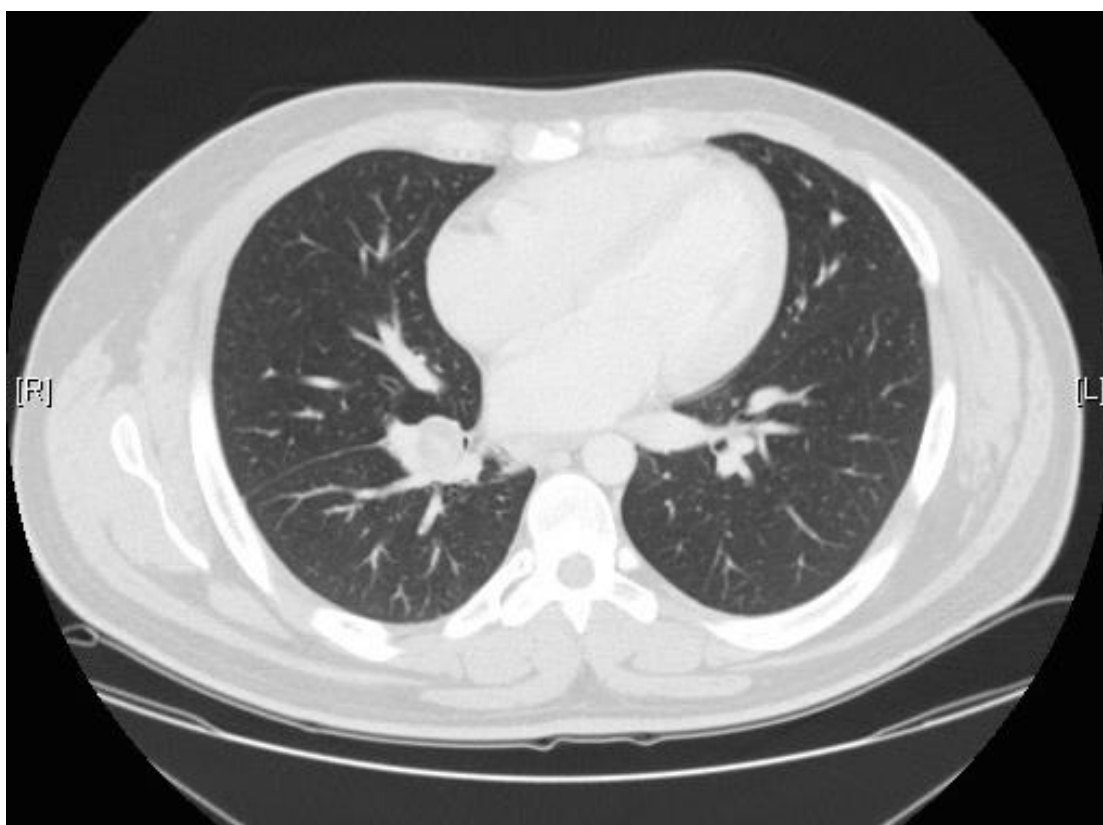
CT showing post-obstruction pneumonia of the right lower lobe
